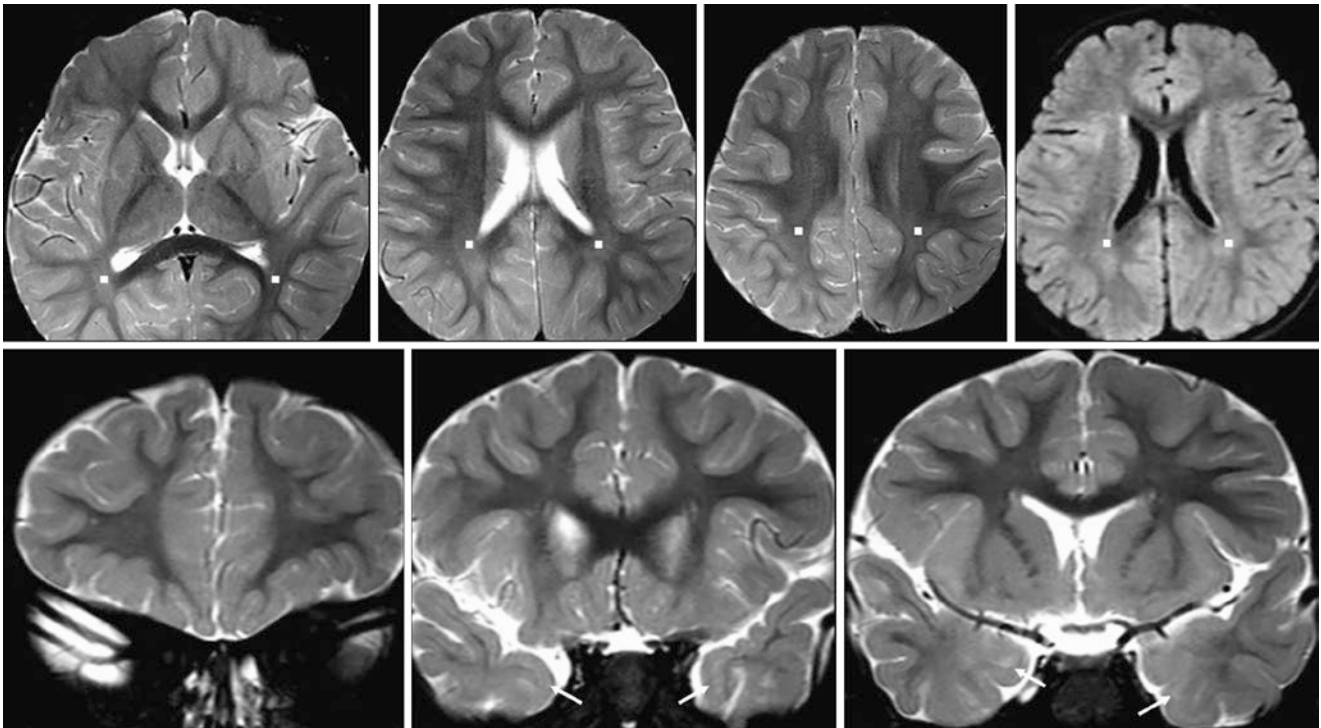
A 23.9-month-old with possible ataxia had a normal 3T MRI. On axial SE T2WIs (*top, left three images*), there were only mild residual peritrial terminal zones (*squares*), which are barely visible on FLAIR (*top, right*). Coronal SE T2WIs show that the patchy SCWM
